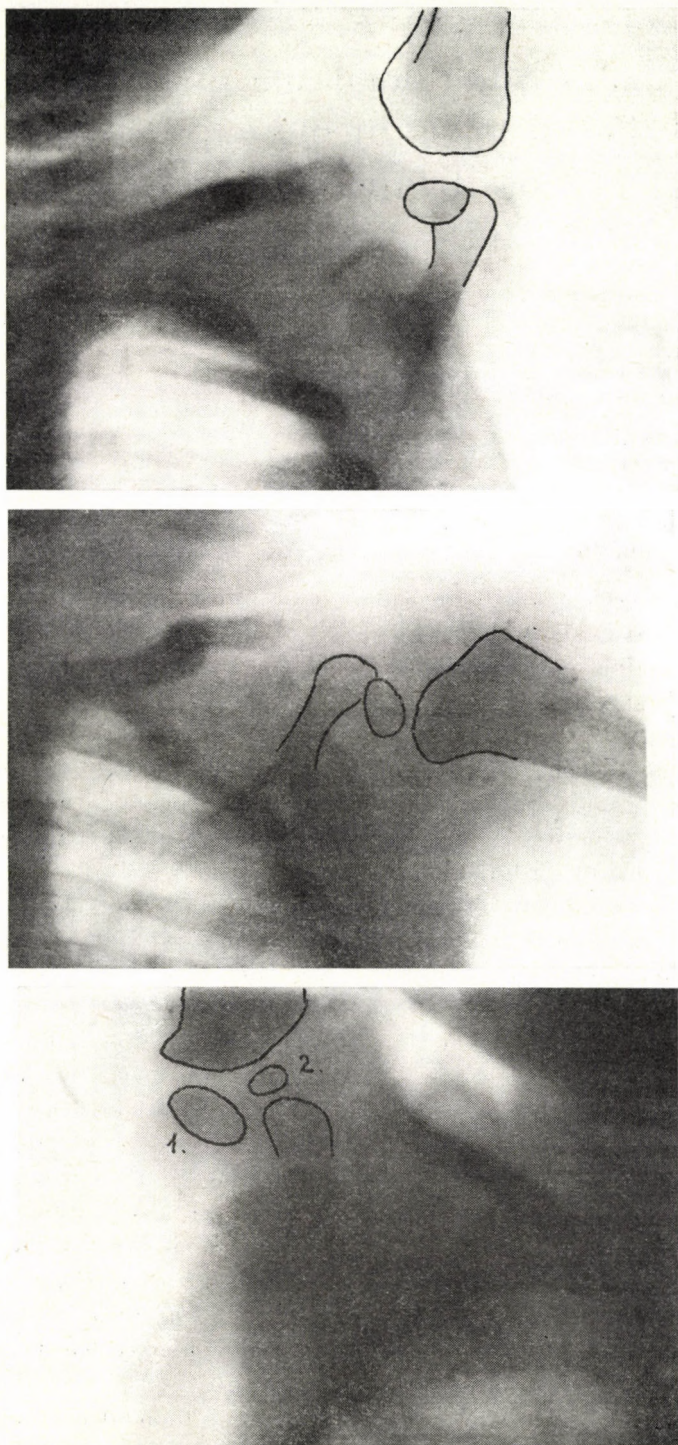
A — p chest roentgenogram of a 7 months (*a-b*) and a 11 months old (*c*) infant *a* upright, *b* recumbent position. The projections of the medial OC of the same infant are similar. *c* Both the medial (1) and the lateral (2) OC have appeared (upright position).
